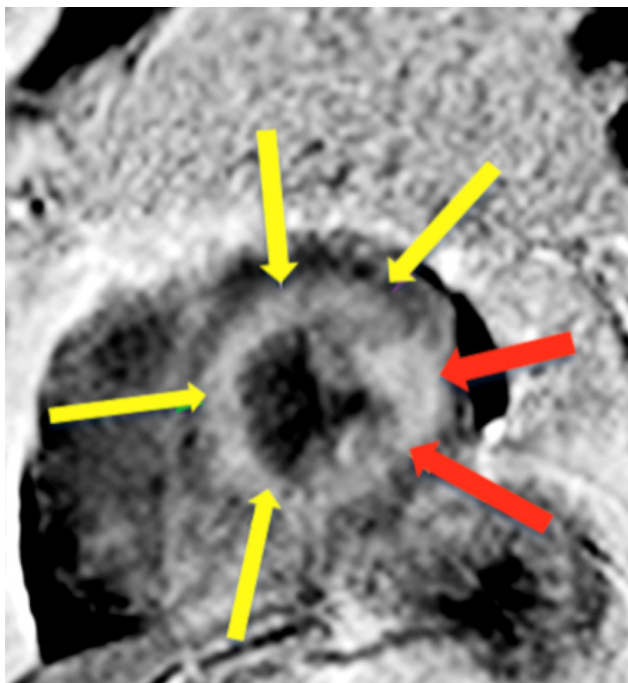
Cardiac magnetic resonance imaging showing LGE with subendocardial (yellow arrows) and transmural distribution (red arrows).
